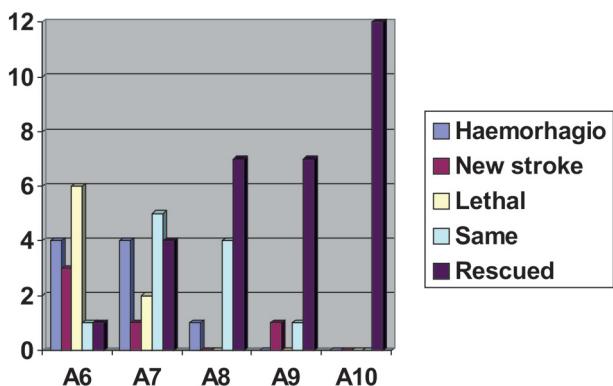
Distribution of patients according to ASPECTS
